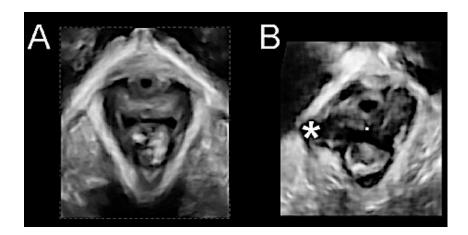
A comparison of ultrasound findings in a normal patient (A) and in a patient with a typical right-sided avulsion (B); rendered volume, axial plane, nd cated by a *. It s ev dent that the morpho og ca abnorma ty documented here s an avu s on of the puborecta s musc e nsert on, e., the musc e has separated from ts bony nsert on. [Perm ss on from Prof HP D etz, 2014 Pe v c F oor Trauma n Childbirth O & G Magazine 2014. Vo ume 16; No 1 Autumn]
